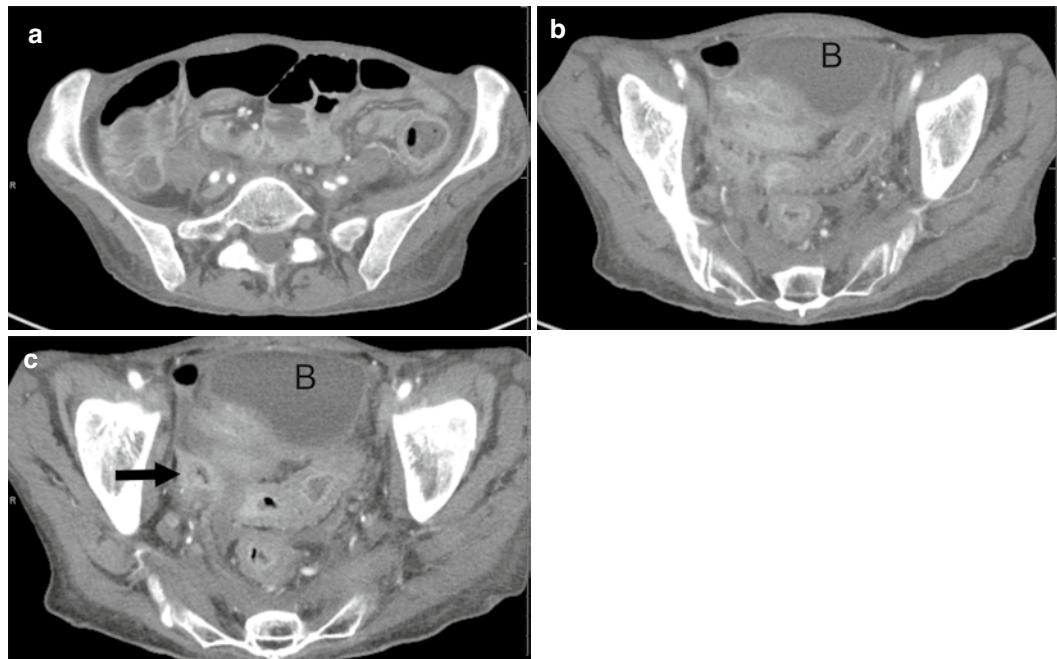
Late radiation change in small bowel. A 55-year-old female with cervical cancer treated with radiation and chemotherapy. Two years after the completion of therapy, the patient developed abdominal pain and weight loss. (a) Axial CTs a and b show small bowel dilation and wall thickening along with rectosigmoid wall thickening. There is also increased pelvic soft tissue. B bladder. (c) Axial CT scan obtained 2 weeks after a and b shows interval development of a small walled off collection with air consistent with contained perforation (arrow)
